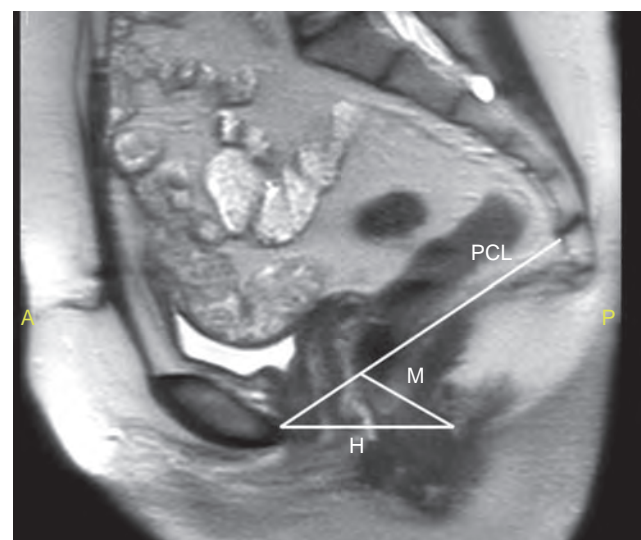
Dynamic half-Fourier acquisition single-shot turbo spin-echo sequence T2-weighted magnetic resonance image in a patient with minor prolapse. H-line measures levator hiatus, M-line measures descent of the levator plate, and PCL measures pubococcygeal line. A, anterior; P, posterior.
